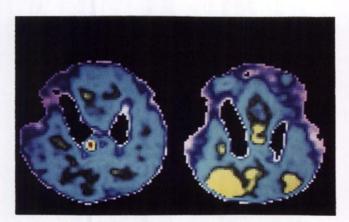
(Left) Subtraction scintigraphy showing a truepositive adenoma of the right lower gland. (Right) False-negative study (also adenoma of the right lower gland).
